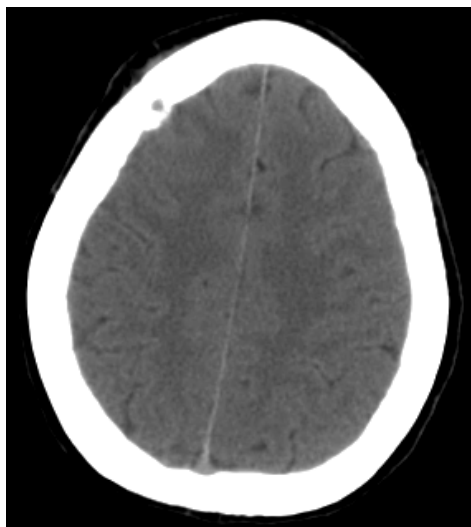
CT of the head on day 8 showing improvement of prior findings as well as right frontal burr hole.
